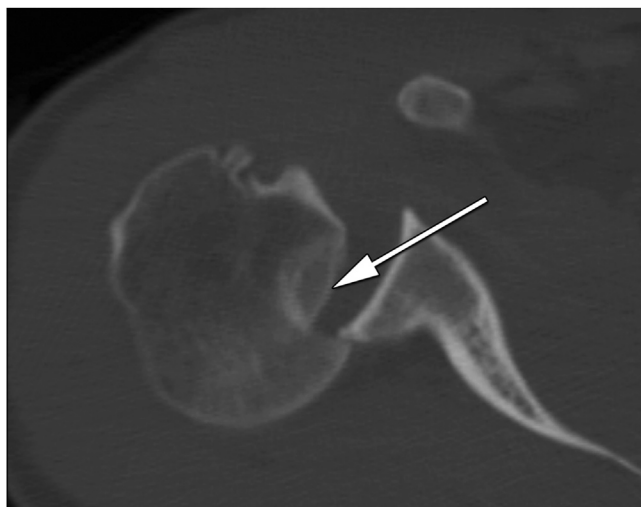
Demonstration of an axial cut of a computed tomography (CT) scan of a locked right shoulder posterior dislocation with a large reverse Hill-Sachs lesion of the humeral head (arrow).
